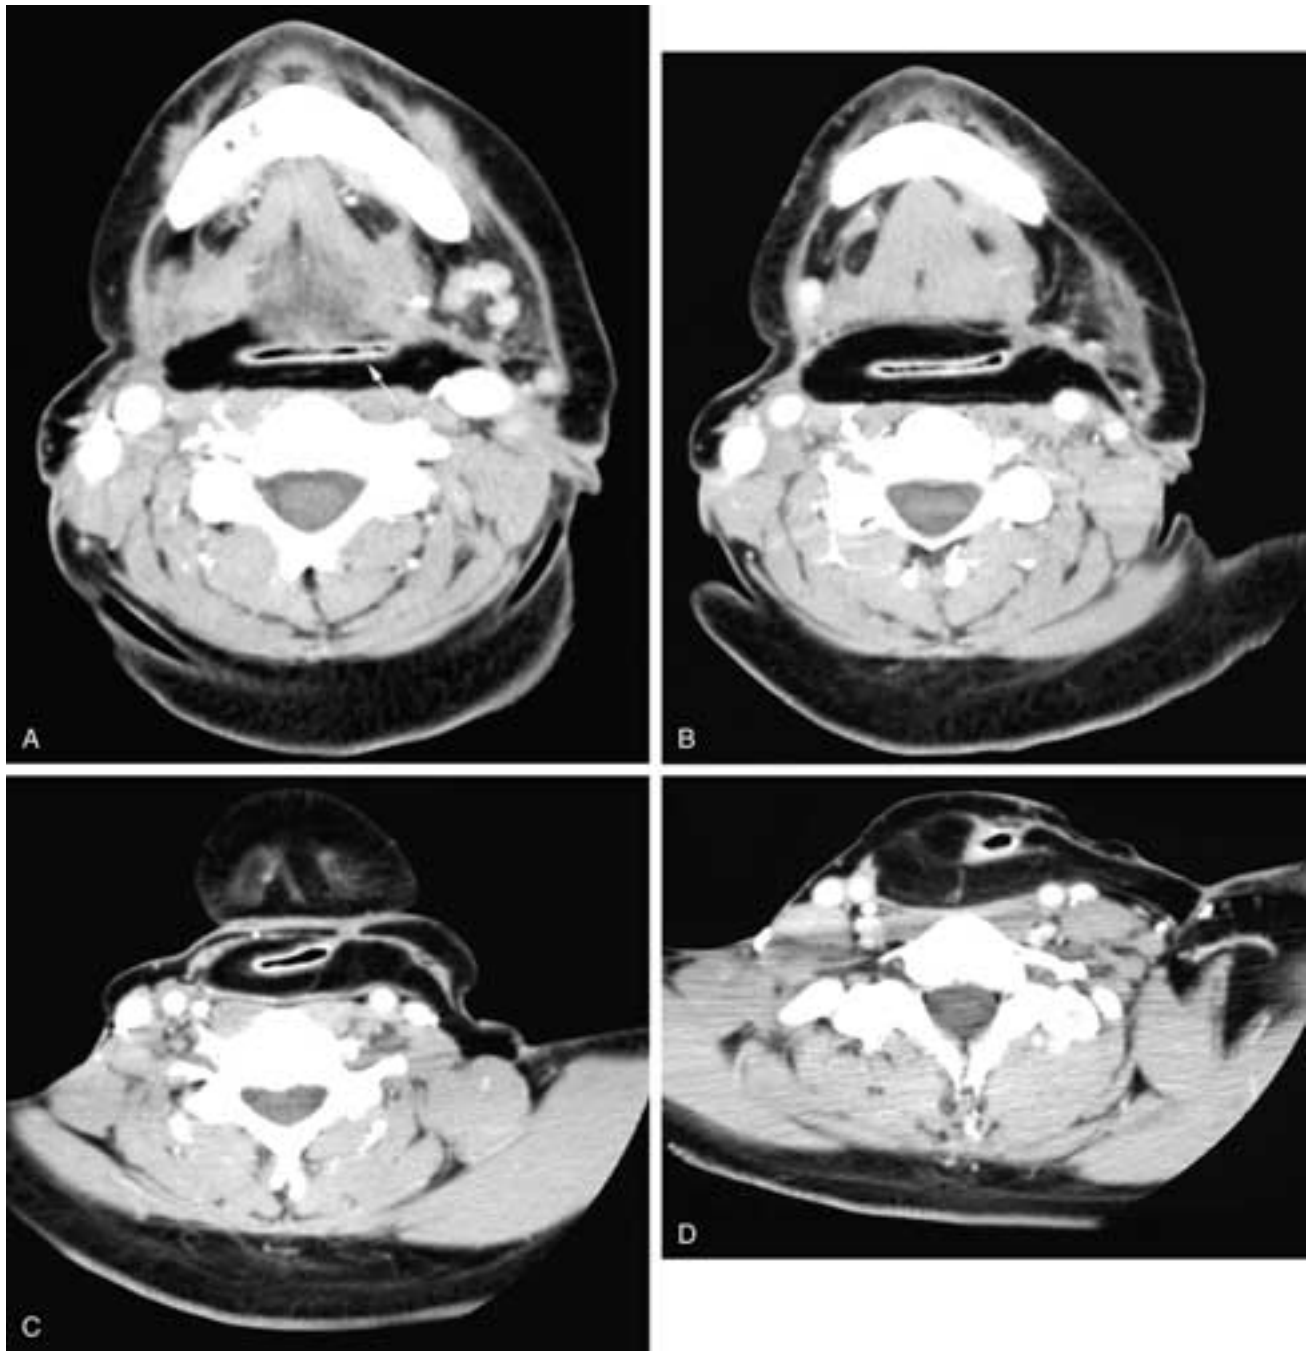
Serial contrast-enhanced CT scans from cranial (A) to caudal (D) on a patient who has had a pharyngectomy and laryngectomy and bilateral radical neck dissections. Note the normal thin, uniform mucosal surface of the flap creating the surface of the neopharynx. Also note the normal circular/ovoid configuration of the fat of the flap as it forms the neopharynx and the sharp margin between the fat and the adjacent soft tissues of the neck. More caudally, note how the flap extends into the more superficial soft tissues of the neck and how, on the left side, the flap covers and protects the carotid artery.
